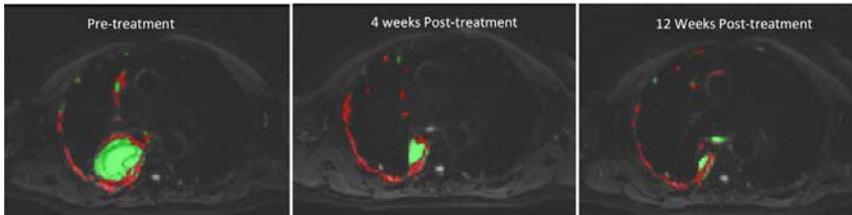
DWI images ($b=100\text{mm}^2/\text{s}$) of a 75-year-old male MPM patient in pre-treatment, 4 weeks and 12 weeks post-treatment scans. The red regions on the $b100$ images represent the classified solid tumour while the green shows the pleural effusions.
